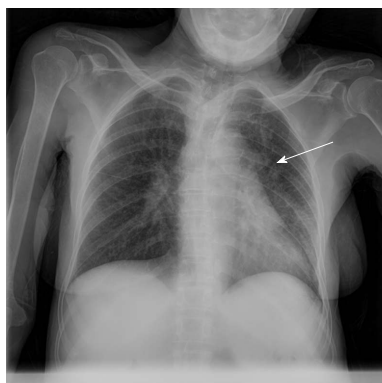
Chest X-ray: Left hilar widening (arrow).
